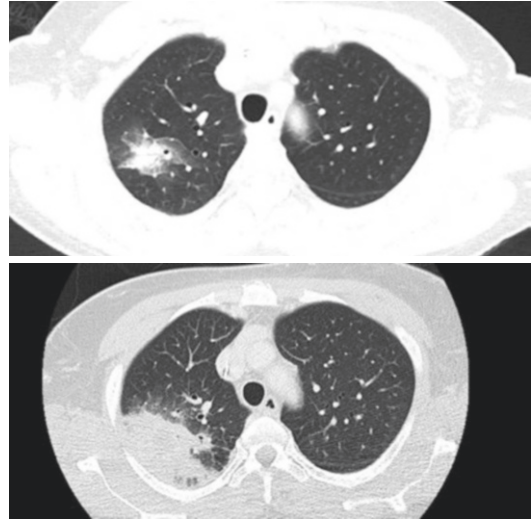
A 71-year-old woman with acute myelogenous leukemia—post induction chemotherapy—top: acute invasive aspergillosis with large nodular infiltrate (neutrophil count 0, with fever and hemoptysis). Bottom: 12 days later, worsening infiltrate (neutrophil count 300/mm³) but improved symptoms. Interpretation of CT needs to be based on neutrophil count
